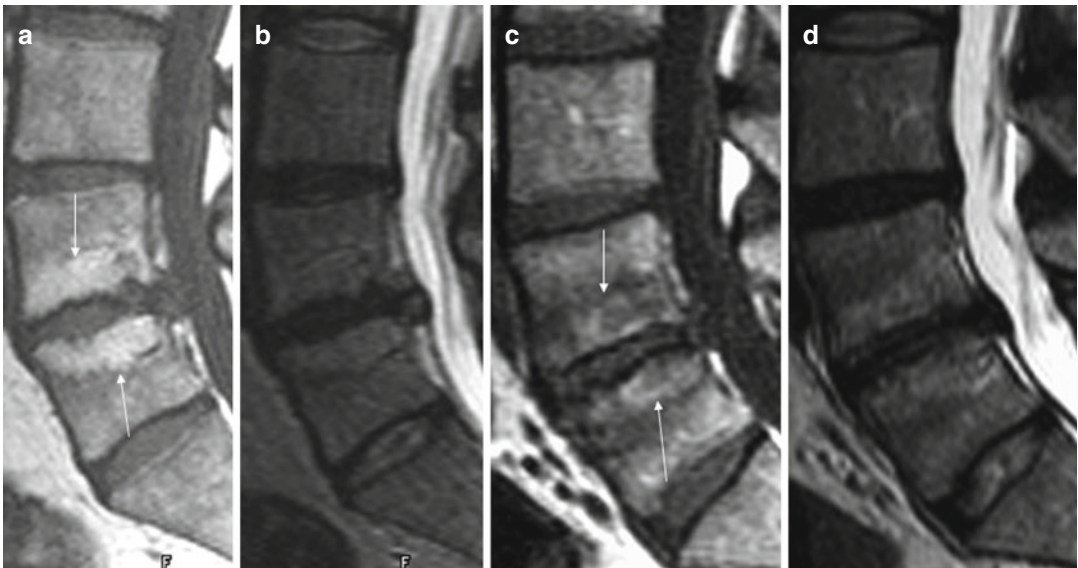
Type II marrow conversion: sagittal midline T1 (a) and T2 (b) spin-echo images of the lumbar spine in a patient with low back pain and radiculopathy. This patient underwent a discectomy at L4/L5 and initially did well but 1 year postoperatively developed recurrent low back pain and was reimaged. Figure 10.5c, d is sagittal midline T1 and T2 spin-echo images which demonstrate a loss of the lipid marrow signal intensity (Fig. 10.5a) typically seen in type II degenerative marrow changes at L4/5. There is now a more mixed signal intensity of the marrow space (c). There is subtle increase signal intensity on the T2-weighted images (d)
